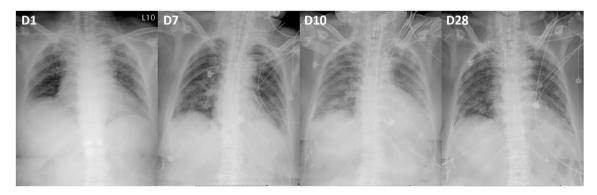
Serial changes in chest radiographs during hospitalization. Starting with left lower lung infiltrates from admission (D1), the patient had progressively increased bilateral middle-lower infiltrates, eventually requiring intubation with mechanical ventilation (D7). Diffuse bilateral infiltrates were noted before intravenous immunoglobulin (IVIg) treatment (D10). These improved, however residual infiltrates persisted after clinical improvement and before extubation (D28). D1: Admission, D7: after elective intubation, D10: before intravenous immunoglobulin (IVIg) treatment, D28: before extubation.
